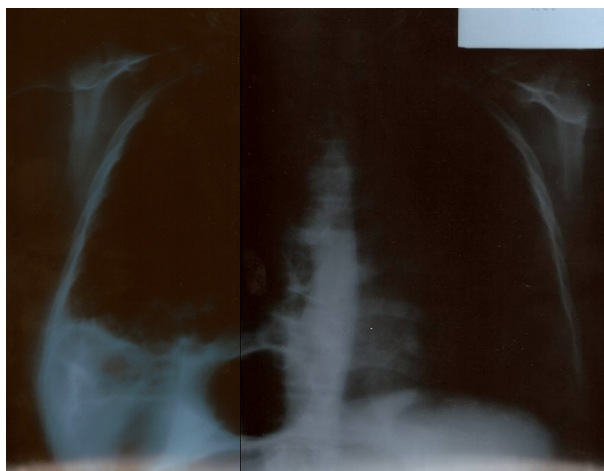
Unexplained air-fluid levels in chest radiography.
